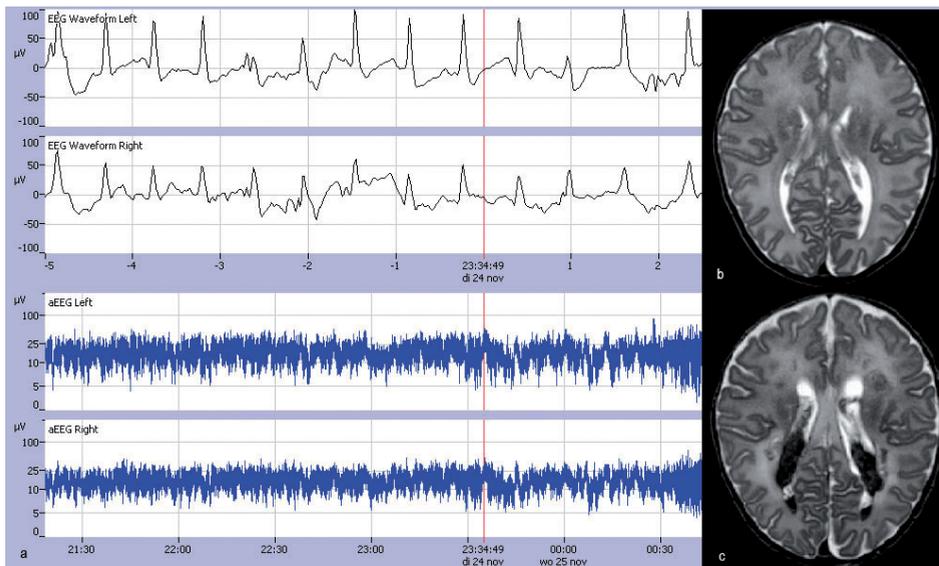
Example of postoperative status epilepticus. a: Approximately 24 hours after surgery, this patient showed a status epilepticus bilaterally on the aEEG, which was treated with phenobarbital. b and c: The pre-operative MRI (b) was unremarkable, whereas postoperatively severe intraventricular hemorrhage and WMI was seen bilaterally (c).
